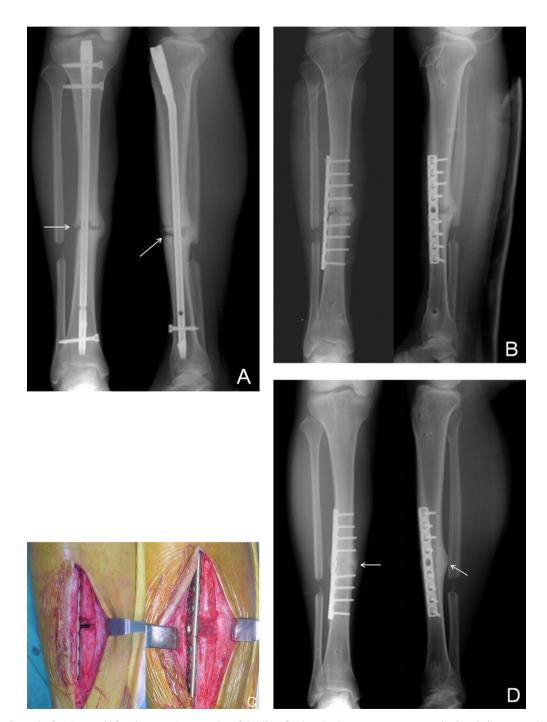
(A) Initial radiograph of a 36-year-old female presenting nonunion of the tibia after lengthening osteotomy to correct leg length discrepancy (11 months after first operation). Arrows indicate the nonunion site. (B) Post-operative radiographs; the previous IM nail was converted to plate fixation with the new tibial bone graft technique (C) Intra-operative photograph demonstrating the nonunion site before and after bone grafting. (D) Radiograph after six months; presenting complete union (arrows).
